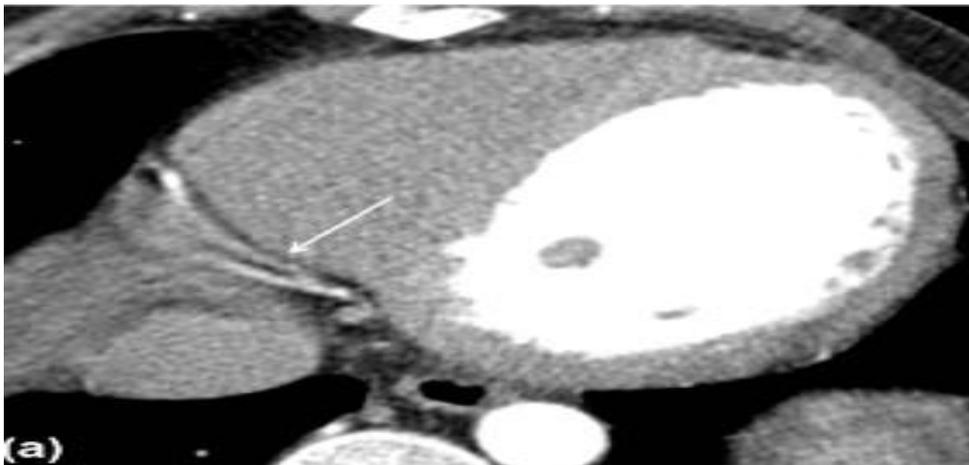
curved planner CT image showing blurring artifact in distal RCA. (21).
